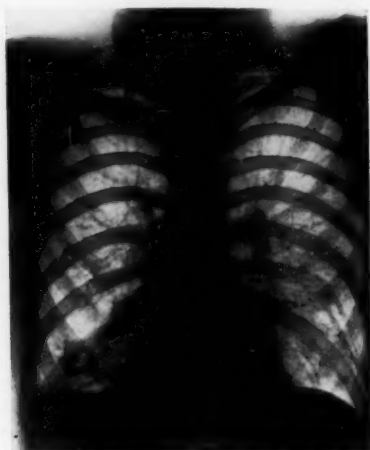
An advanced case of bronchiectasis. This is readily recognized in the Roentgenogram.
